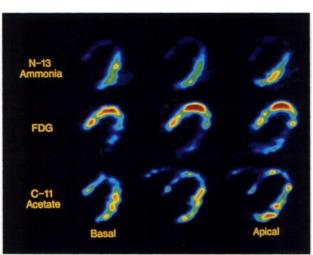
Midventricular transaxial N-13 ammonia, F-18 deoxyglucose, and early C-11 acetate images in a patient with an acute anteroseptal Q-wave infarction. With NH3, a large perfusion defect is identified in the anterior wall and septum. Prominent uptake of FDG in this region indicates metabolic viability. Early C-11 acetate images are similar to N-13 ammonia perfusion images.
